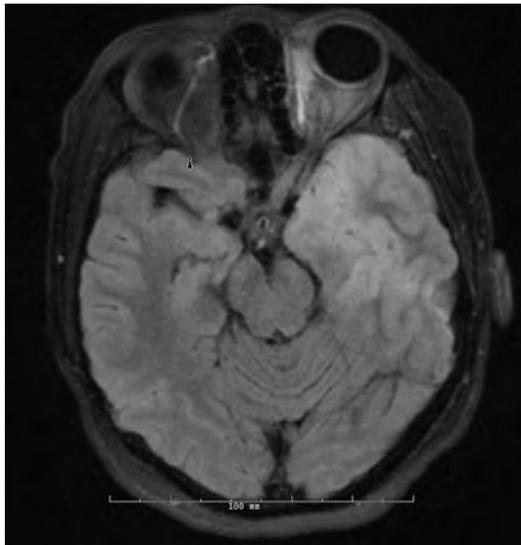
MRI (FLAIR sequence) of a 21-year-old woman with HSV-1 encephalitis. There is increased T2 signal due to edema especially in the medial right temporal lobe, with early uncal herniation. (Courtesy of Thomas Bleck, MD.)
